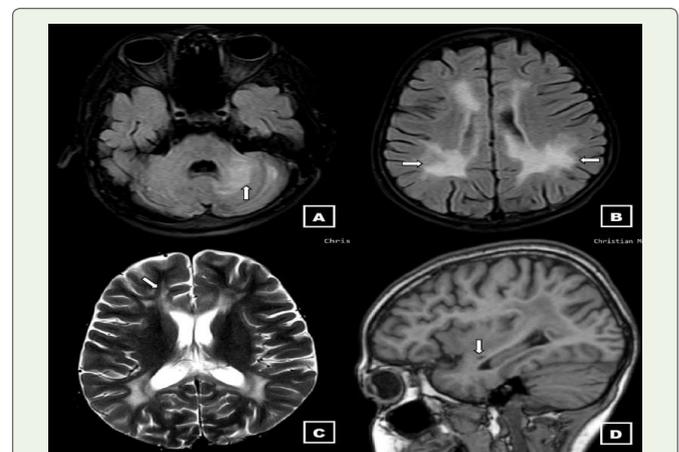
MRI Brain of the patient in January 2020 has done at a referral hospital. A) Axial T2 FLAIR image at the level of the 4th ventricle shows hyperintensity in left cerebellar white matter and left cerebellar peduncle (arrow). Note – there is a resolution of right middle cerebellar peduncle hyperintensity as compared to the previous scan (Figure 3A) B) Axial T2 FLAIR image at the level of the body of lateral ventricles show confluent symmetrical hyperintensities in B/L corona radiata (arrows). C) Axial T2W image at the level of the internal capsule shows hyperintensity along the subcortical U-fibre of the right frontal lobe (arrow). Subcortical U-fibre involvement is classically described in cases of MS [2]. D) Sagittal T1W image shows hypointense small focus in the periventricular white matter of right temporal lobe, thus giving a classical appearance of “T1 black hole sign” (arrow). This finding is seen in demyelinating diseases with relapsing and remitting courses and is classically described for MS [6].
